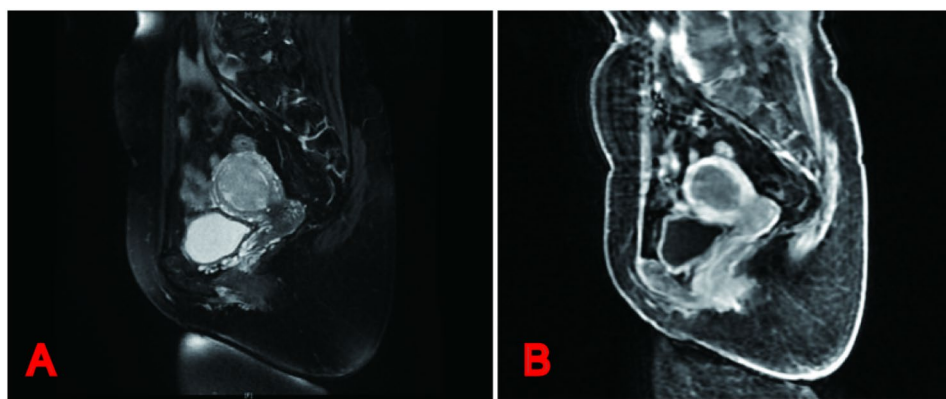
Pelvis magnetic resonance imaging showing heterogeneously enhancing mass occupying the uterine cavity. (A) Sagittal T2-weighted image. (B) Sagittal contrast-enhanced T1-weighted image
